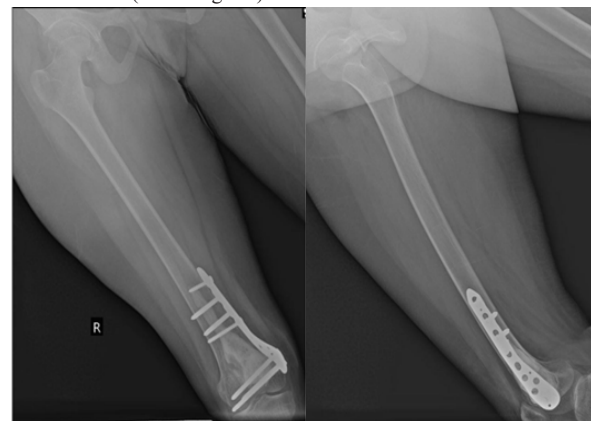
4 months follow up X-Rays showing satisfactory incorporation of bone graft and cement in situ with fixation using plate in well alignment with no evidence of recurrence of tumor
